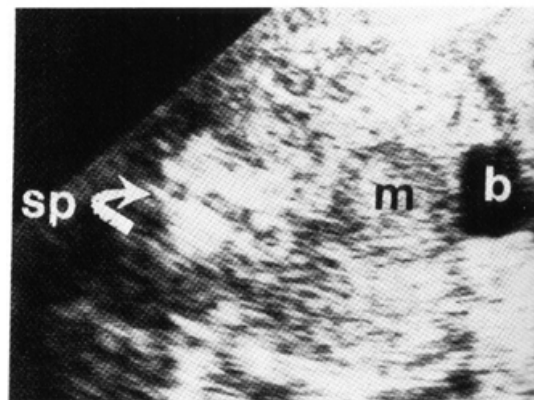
Transverse scan through the fetal lower abdomen. A solid mass (m) is seen behind the bladder (b). sp, spine. (Reproduced with permission from Hill, Hirsch: *J Ultrasound Med* 4 :323. 1985.)
